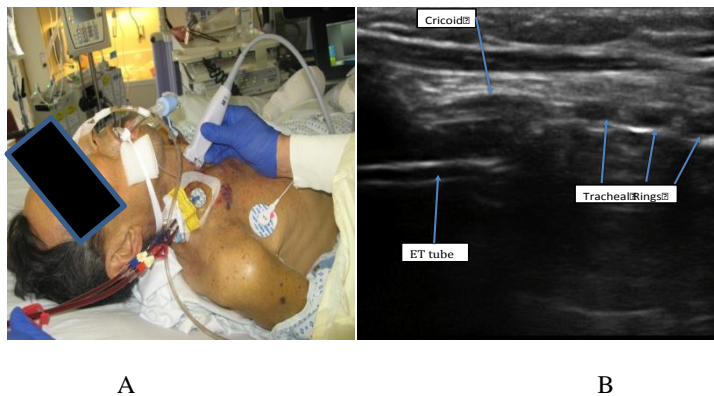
The ultrasound probe is placed on the neck in the longitudinal plane (A) and anatomy is identified on ultrasound (B).
